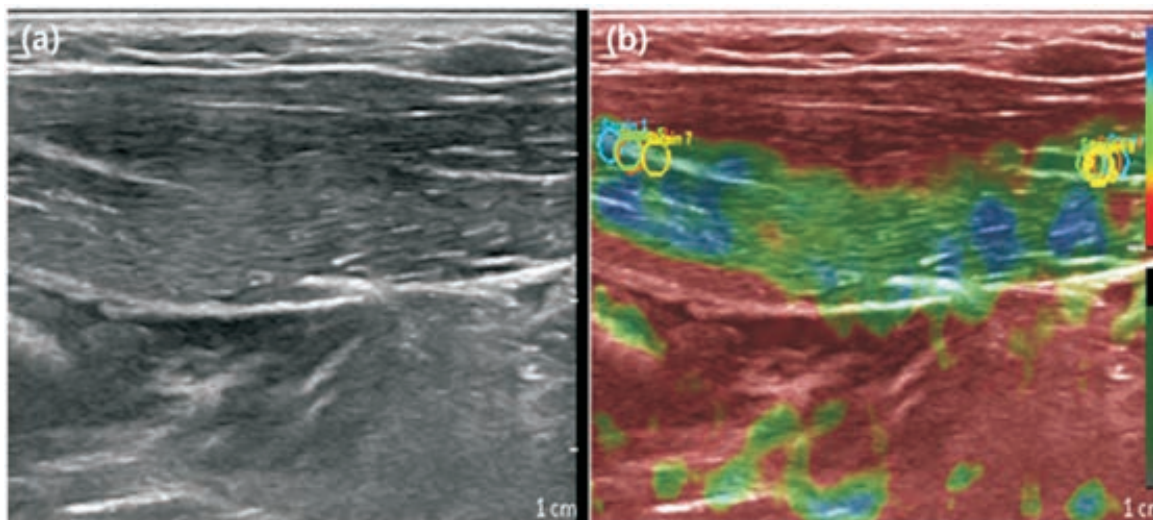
Ultrasound image (A) and Elastography image (B) of a forearm after infrared therapy³⁶.
